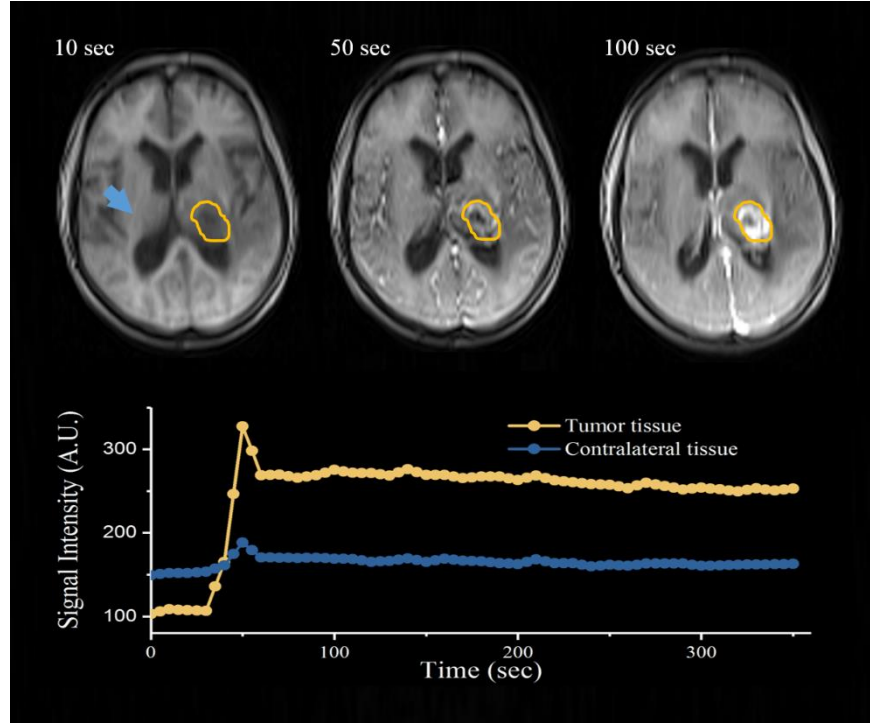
Dynamic contrast-enhanced MR images for brain tumor. The top row shows an example transaxial slice acquired at 10 sec, 50 sec, and 100 sec following the contrast agent administration. The bottom row demonstrates the signal intensity vs. time curves for tumor tissue (yellow) and healthy tissue (blue).
